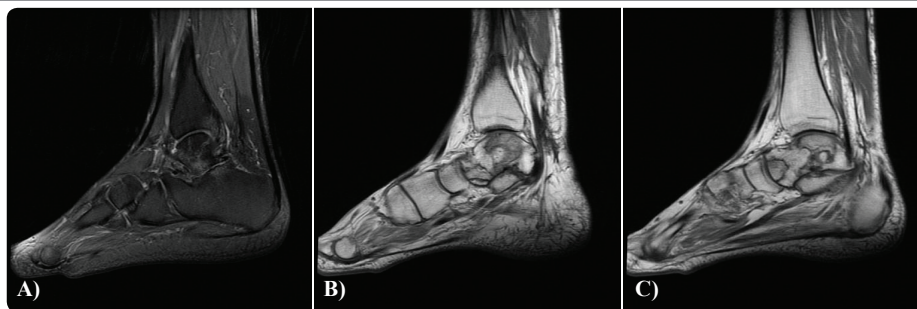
MRI images showing AVN of talus and subtalar arthritic changes.
